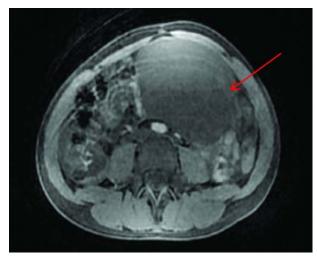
Abdominal and pelvic MRI showing the mass in the lower abdomen and pelvis
